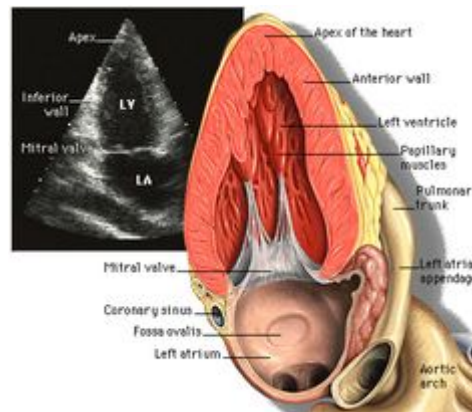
Normal apical 2-chamber view.(Feigenbaum2010)
